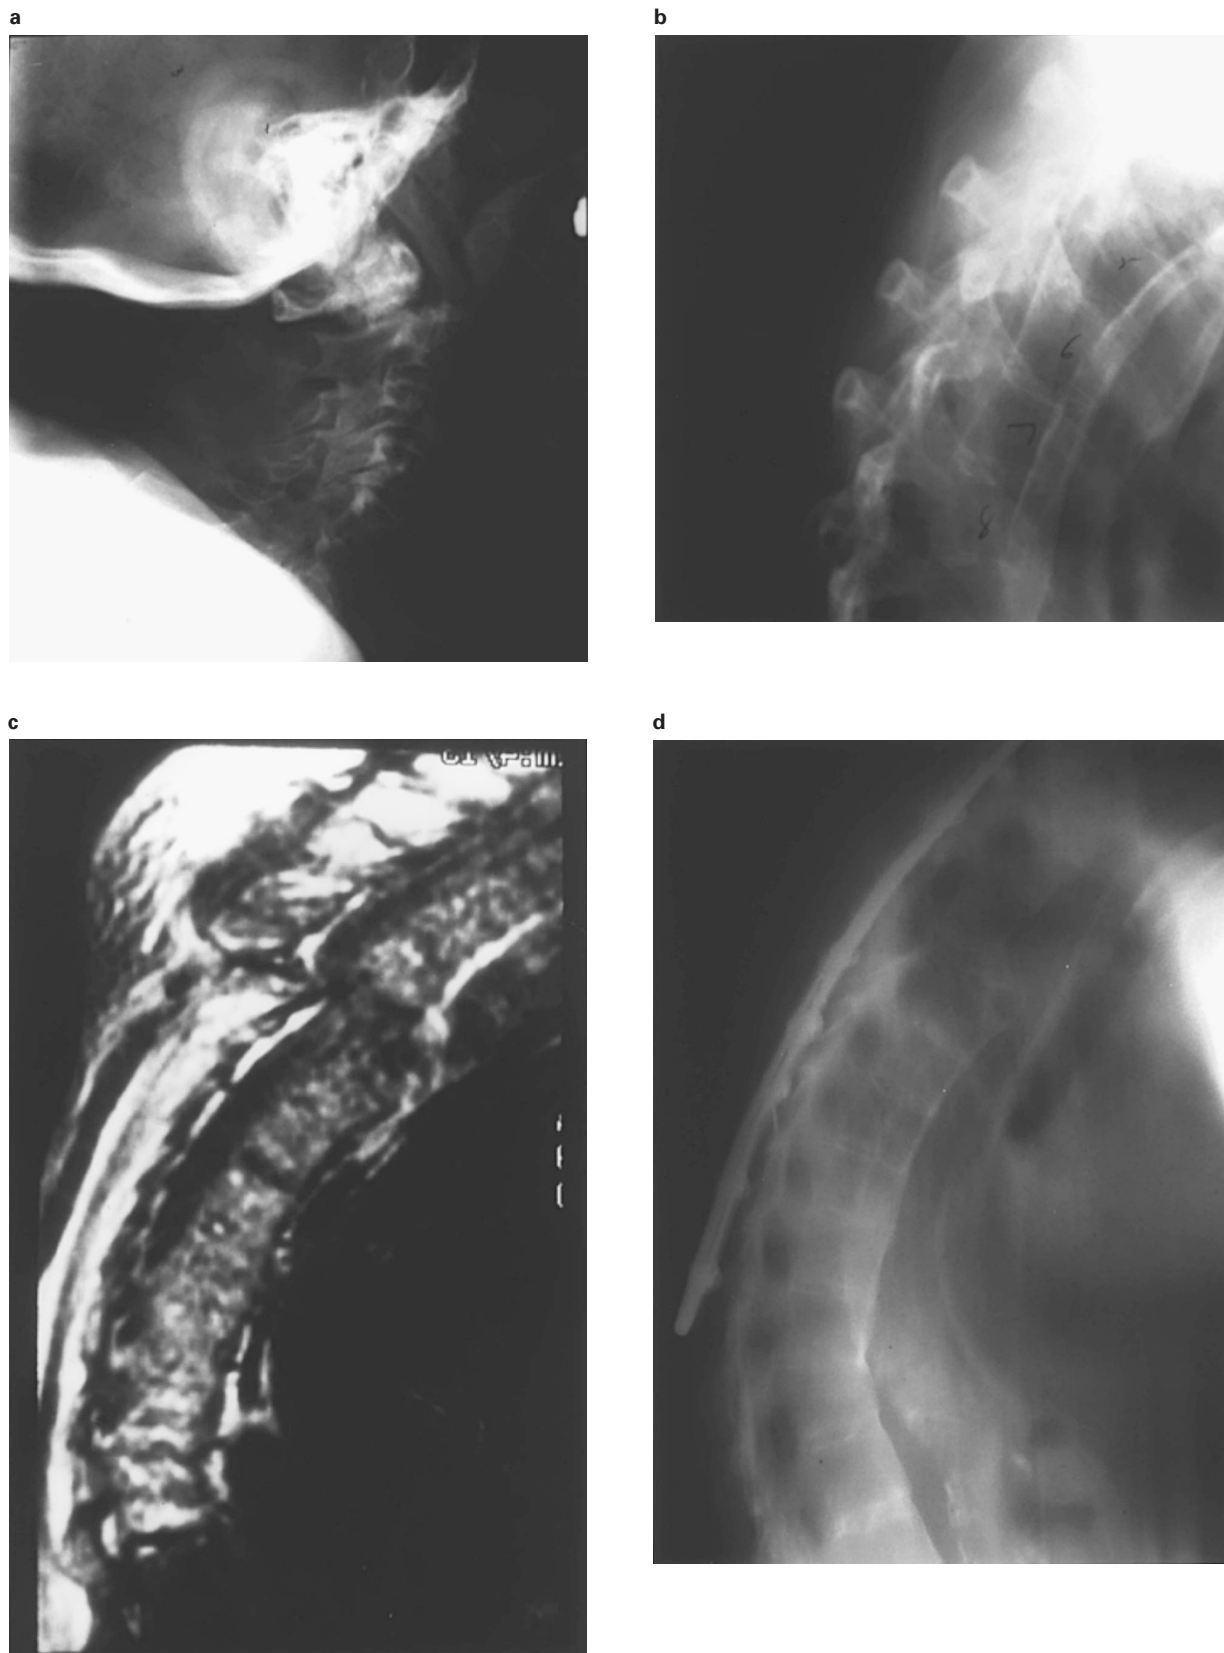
(a) Cervical spine lateral radiograph with posterior displaced Type II odontoid fracture. (b) Lateral thoracic spine centred at T6 demonstrating ankylosing spondylitis without obvious fracture or dislocation. (c) Following neurological deterioration, MRI demonstrates fracture dislocation at T5–6. (d) Post-operative lateral radiograph following decompression and instrumentation
